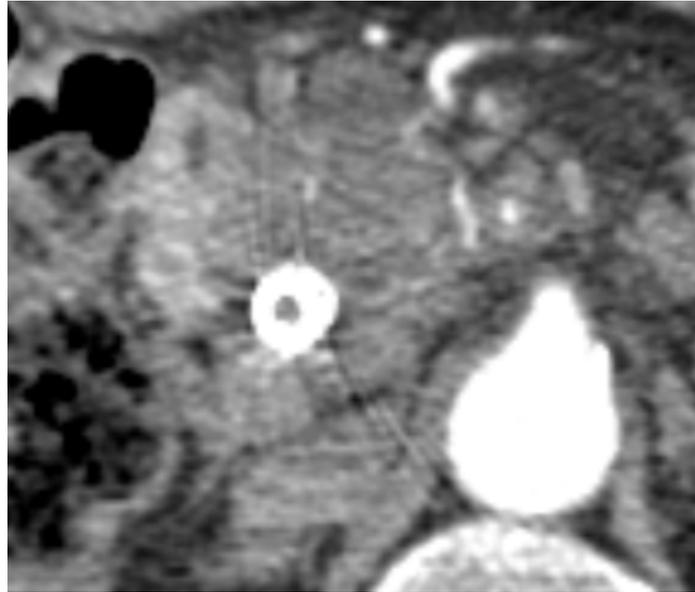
Contrast CT scans of a patient with the Cotton Huibregtse biliary stent, showing radial striation beam-hardening artifacts around the stent location. The stent is the bright ring near the center of the image.
